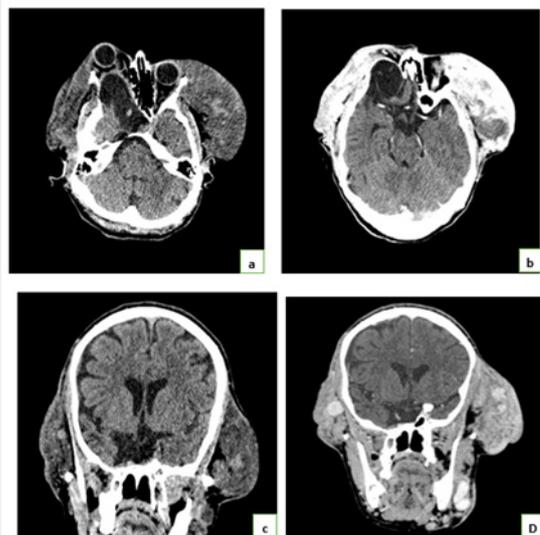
Cerebral CT scan in axial cut before(a)and after injection of PDC (b)and coronary before(c)and after injection of PDC (dd) showing bilateral frontal-temporal facial angio-fibroids heterogeneous hypodense(a and c),having intense contrast after PDC (c and d) associated with an unenhanced right frontotemporal cystic tuber after PDC exerta mass effect on the homolateral eyeball responsible for grade III exophthalmia (a and b).).
